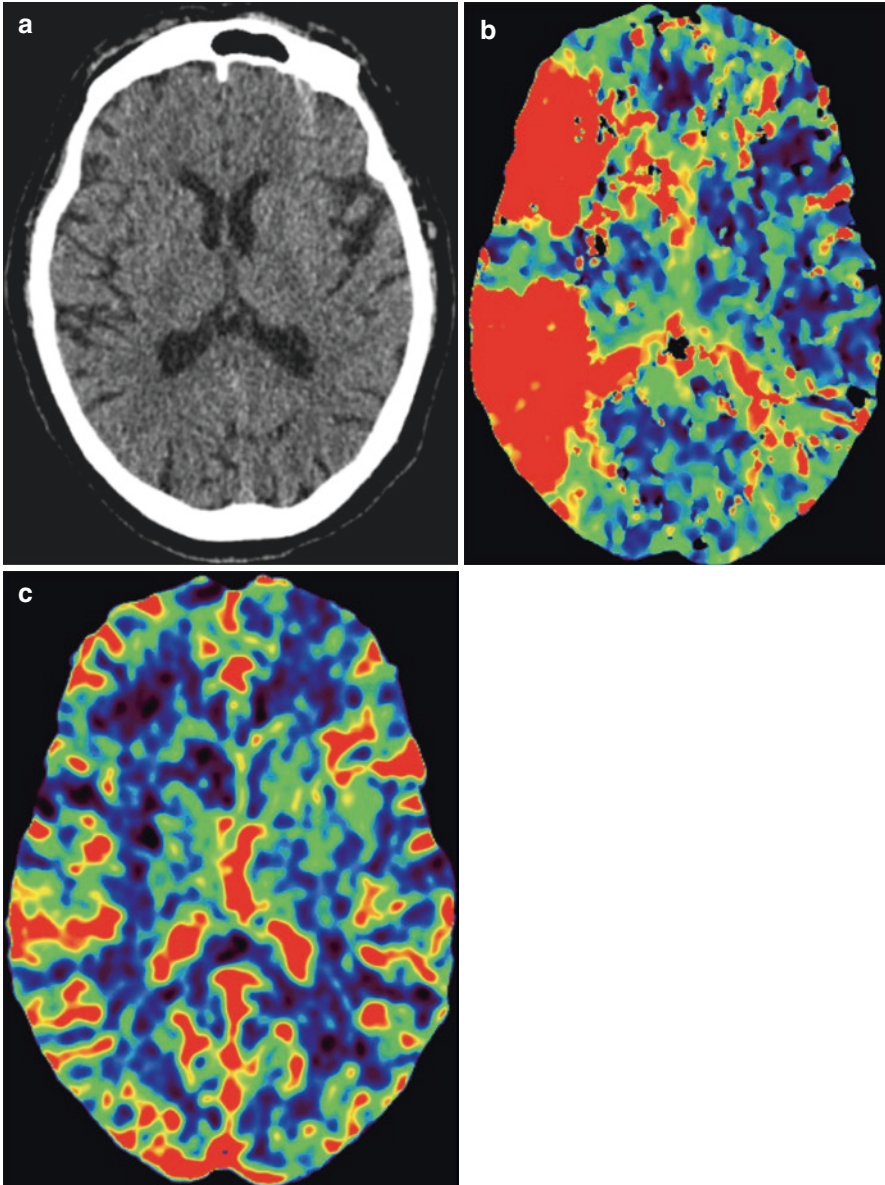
(a) Non-contrast CT head demonstrates no evidence of intracranial hemorrhage. (b) CT head perfusion sequence demonstrates an increase time to peak in the distribution of the right middle cerebral artery. This is represented as red in the distribution of the right middle cerebral artery. (c) CT head perfusion demonstrates preserved blood volume in the right middle cerebral artery. Low blood flow would be represented as dark blue, as is seen in the subcortical white matter under normal physiologic conditions. The finding of increased time to peak in the setting of preserved cerebral blood volume suggests the presence of an ischemic penumbra
